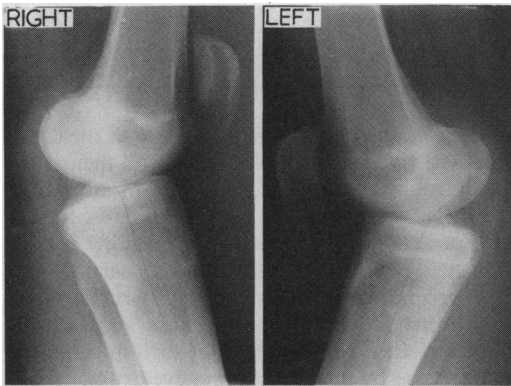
Lateral radiographs of the right and left knees
